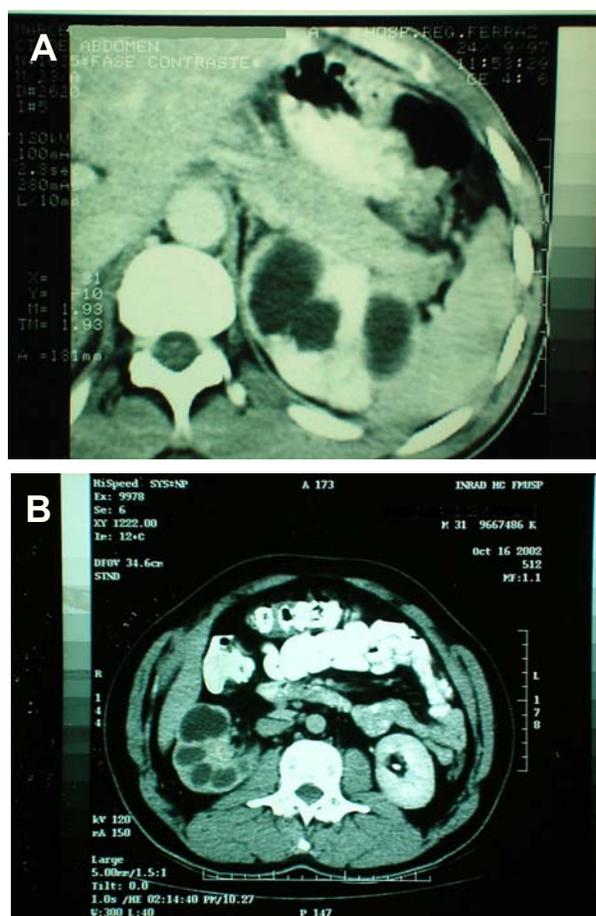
A) and B) Computed tomography showing unilateral renal tuberculosis with low function kidney with dilatation of the excretory system in two different patients.
